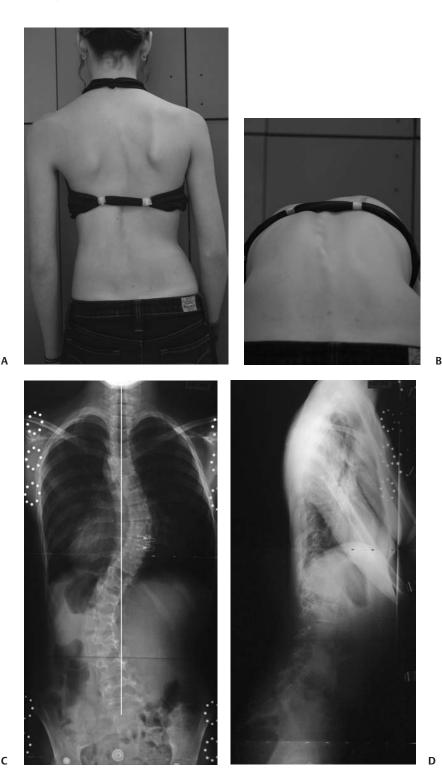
(A,B) Preoperative PA and forwardbending clinical photographs and (C,D) PA and lateral radiographs of a 14-year-old girl demonstrate a 49-degree thoracic and 44-degree thoracolumbar curve (Lenke type 1C deformity). The thoracic curve bends to 17 degrees (65% flexibility) and the lumbar curve bends to 13 degrees (70% flexibility). Nonselective posterior spinal instrumentation and fusion with segmental pedicle screws from T5 to L4 was done in this case because of the large apical (L2) deviation of the lumbar curve from the CSVL (4.0 cm), large preoperative clinical lumbar prominence (17 degrees), and low ratio of the thoracic-to-lumbar curve magnitude (1.1).
